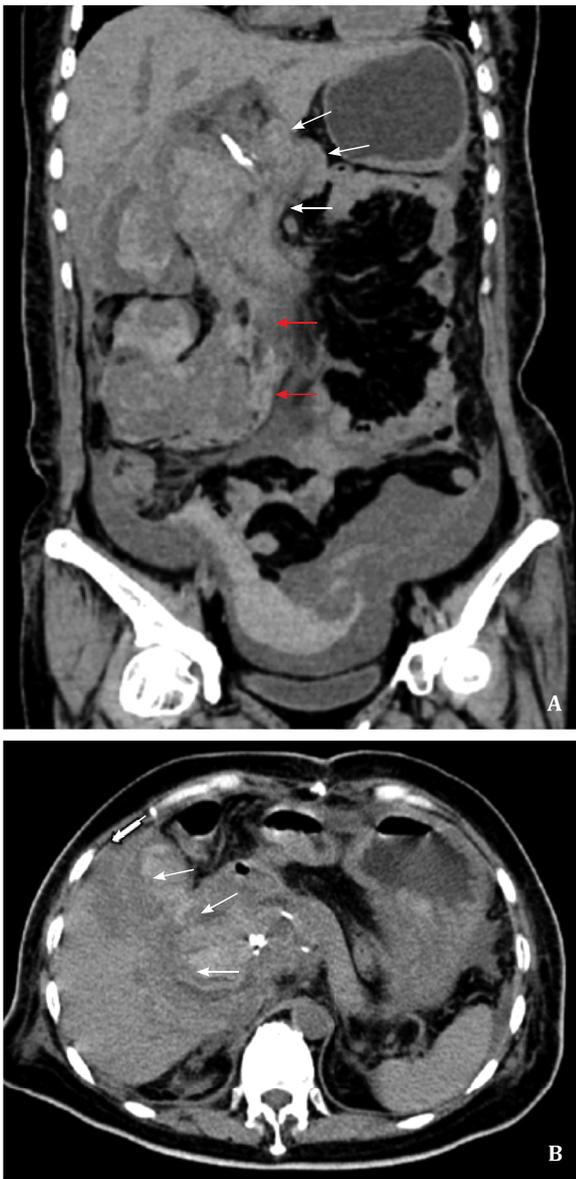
Computed tomography performed on postoperative day 37. A: In the coronal plane, computed tomography indicated perihepatic hematoma (white arrows) and multiple hematomas in the abdominal cavity (red arrows); B: In the horizontal plane, computed tomography indicated perihepatic hematoma (white arrows).
